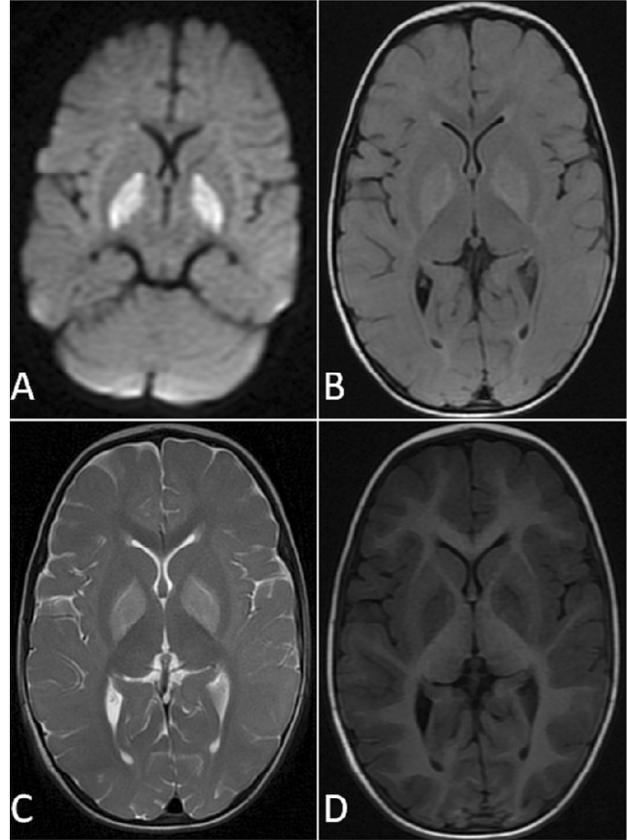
A Two-year-old term female child brought to the hospital with seizures and a history of foreign body inhalation that caused asphyxia. The patient underwent MRI scan (A) Diffusion-weighted image shows symmetrical areas of restricted diffusion in bilateral globus pallidus (B) Axial FLAIR and (C) Axial T2-weighted images demonstrating markedly increased signal intensities in bilateral globus pallidus with low signal intensities on corresponding T1-Weighted image.
